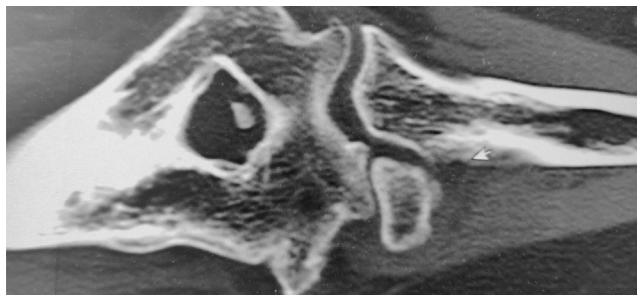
CT scan reveals healing of the vascularized graft.
